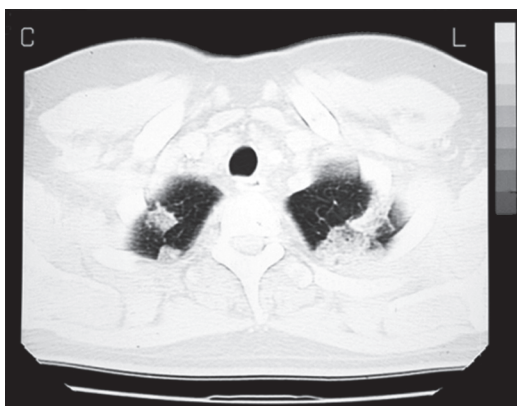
Chest CT scan revealing condensation in the upper third of both lungs.
